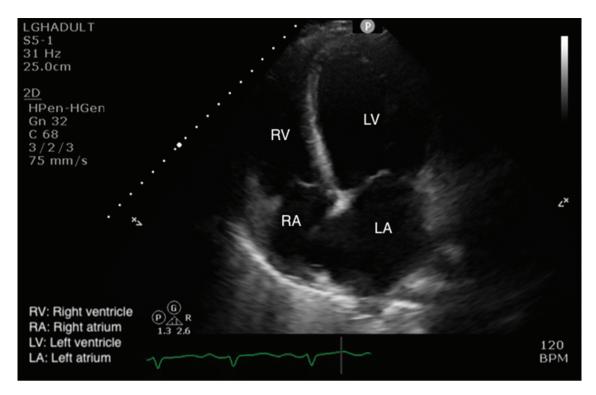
Apical four chamber view echocardiogram. Here we can see global chamber enlargement with accompanying thinning of the myocardium. In addition, the utilization of color Doppler in this view showed both mitral and tricuspid regurgitation. These findings are often seen in dilated cardiomyopathies, which peripartum cardiomyopathy falls within. RV, right ventricle; RA, right atrium; LV, left ventricle; LA, left atrium.
